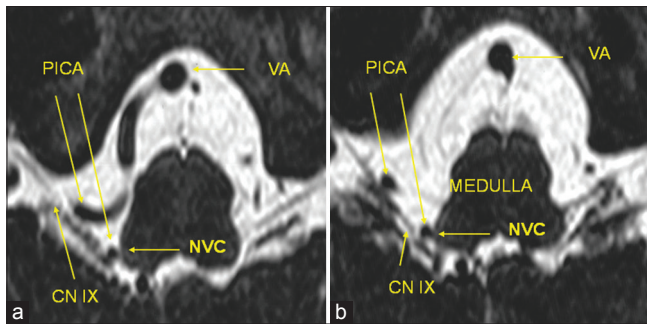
High-resolution magnetic resonance imaging with constructive interference in steady state sequence with neurovascular compression of the right-sided glossopharyngeal nerve. (a and b) A right-sided posterior inferior cerebellar artery-loop originating from the vertebral artery and coursing into the root entry zone of the glossopharyngeal nerve at the ventrolateral medulla oblongata. VA: Vertebral artery, PICA: Posterior inferior cerebellar artery, CN IX: Glossopharyngeal nerve, NVC: Neurovascular compression
